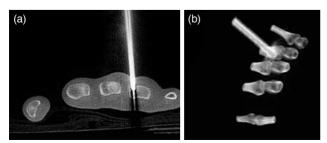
Computed tomographic (a) axial plane image (b) three-dimensioned volume rendering technique image shows the bone biopsy needle within the nidus.
